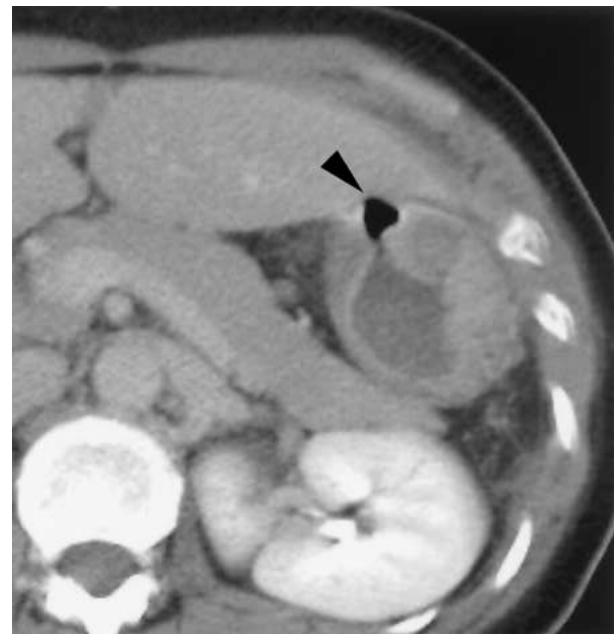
Contrast-enhanced abdominal CT image of a patient with perforated gastric peptic ulcer disease. Discontinuation of the gastric wall is caused by a deep ulcer (arrowhead) associated with surrounding mural thickening.
